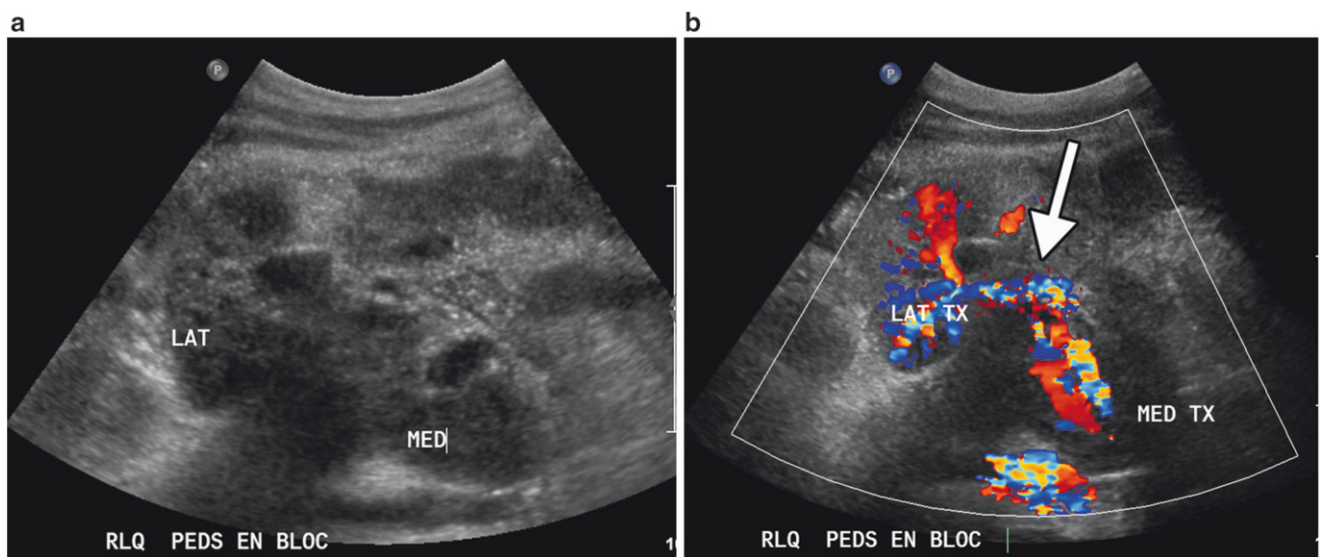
Pediatric en bloc renal transplants. (a) Gray scale image of the two renal transplants (*LAT*, *MED*) shows the hila facing each other. (b) Color Doppler image shows the vascular anatomy with donor aorta and vena cava (*arrow*)
